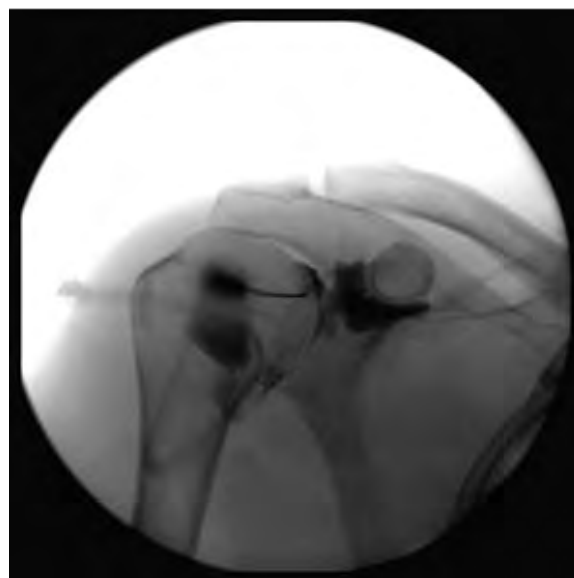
Fluoroscopic image of needle placement and contrast injection into the shoulder joint capsule before undergoing MRI examination.
